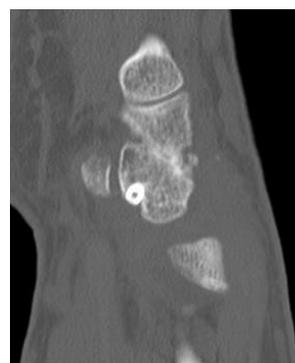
Pisotriquetral screw penetration.* Postoperative development of pain at the pisotriquetral joint. Sagittal computed tomography images show marginal intra-articular penetration of the screw.
